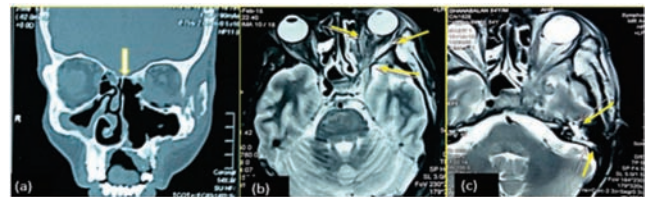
a) coronal CT showing hypointense mass causing erosion of right maxillary sinus, ethmoidal sinus and palate
